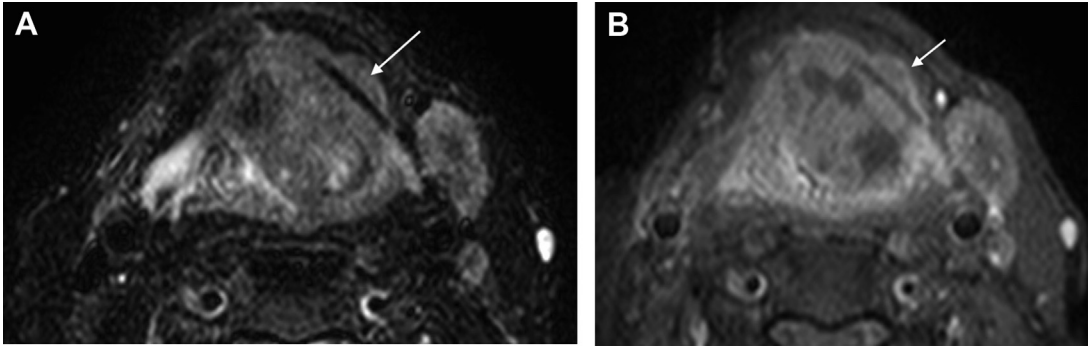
MR imaging of cartilage invasion. Axial STIR and T1 postcontrast fat-saturated images (*A, B*) showing transglottic cancer obstructing the airway and transfixing the left thyroid cartilage (*white arrows*) with intermediate T2 signal and heterogeneous enhancement.
